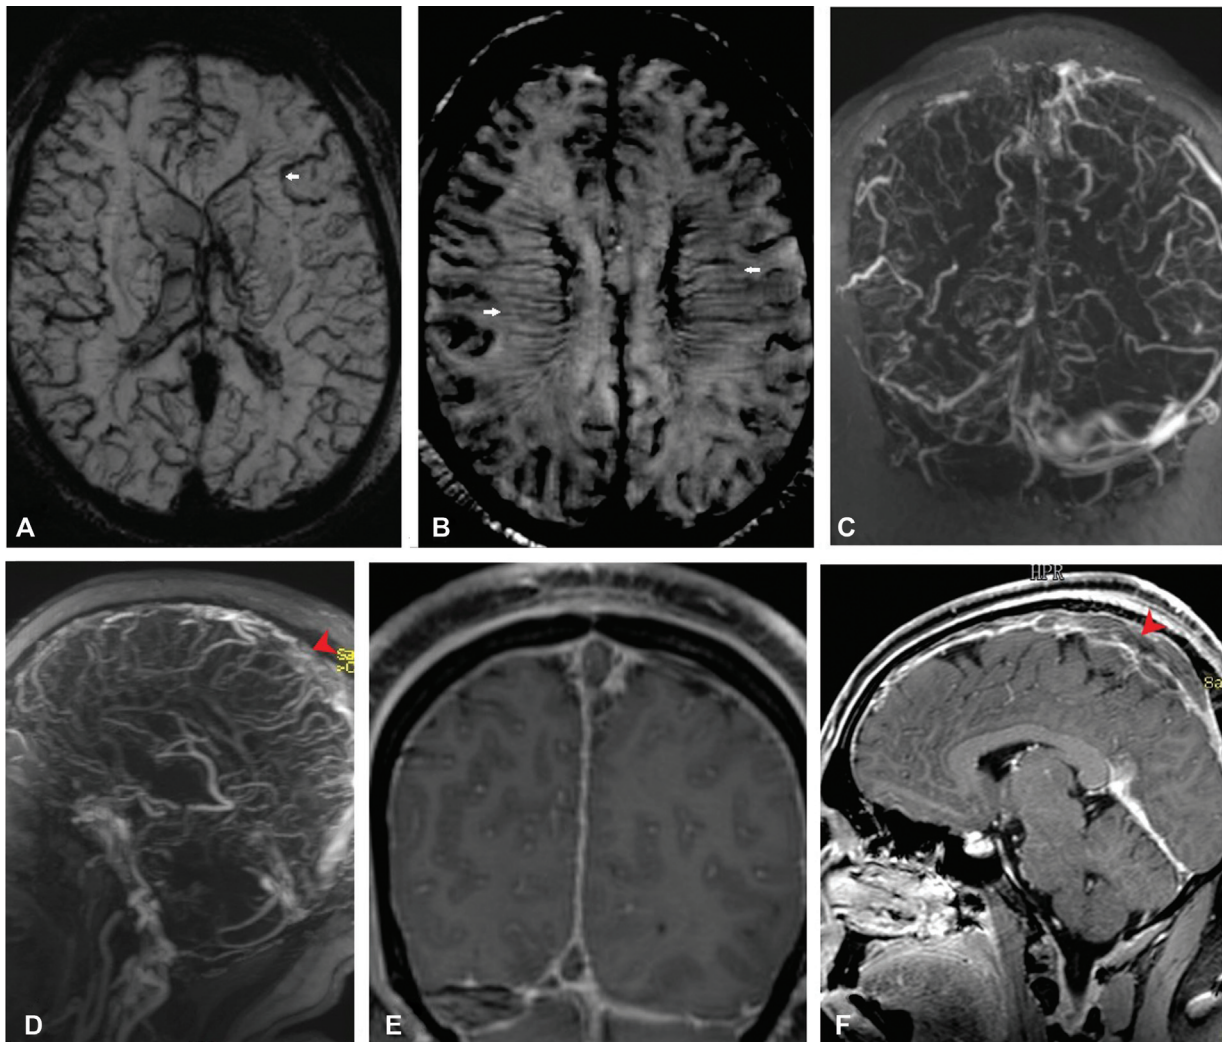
(A, B) Axial gradient echo sequence (GRE) images show dilatation with blooming artifacts seen in the superficial cortical veins of both the cerebral hemispheres due to congestion (*small white arrows*), the brush sign. (C, D) Contrast magnetic resonance venography (MRV) coronal and sagittal images and (E, F) postgadolinium sagittal and coronal T1-weighted images show replacement of normal flow-related signal void and absence of contrast opacification of these segment of the dural venous sinuses suggestive of thrombosis involving superior sagittal sinus (*red pointed arrowheads*), torcular herophili, and right-sided transverse sigmoid sinus, proximal third of the left transverse sinus and straight sinus, and vein of Galen, also extending to the right internal jugular vein.
